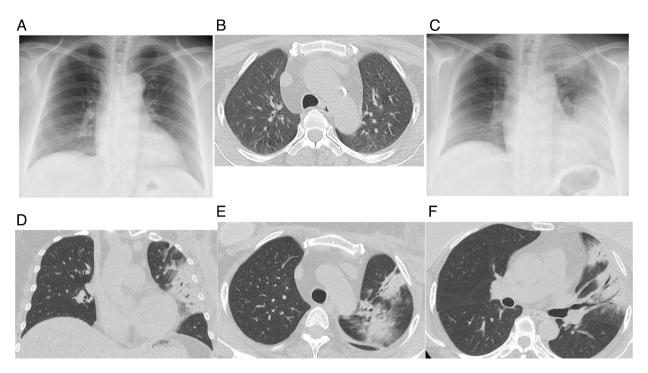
CT findings and chest radiograph findings. (A) Chest radiograph and (B) chest CT taken before the initiation of radiation therapy and abemaciclib treatment. (C) Chest radiograph revealing extensively decreased transparency throughout the left lung. Chest CT showing infiltrative shadows with bronchial transparency corresponding to the radiation-exposed area. (D) Coronal view. (E) Axial view. (F) Axial view.
